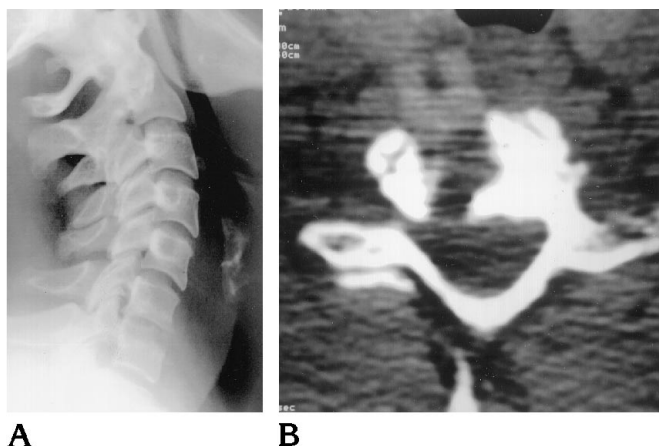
A, Lateral radiograph of the cervical spine. There is widening of the prevertebral soft tissue space at C6-7, the level of the previous cervical fusion and BOP insertion.
